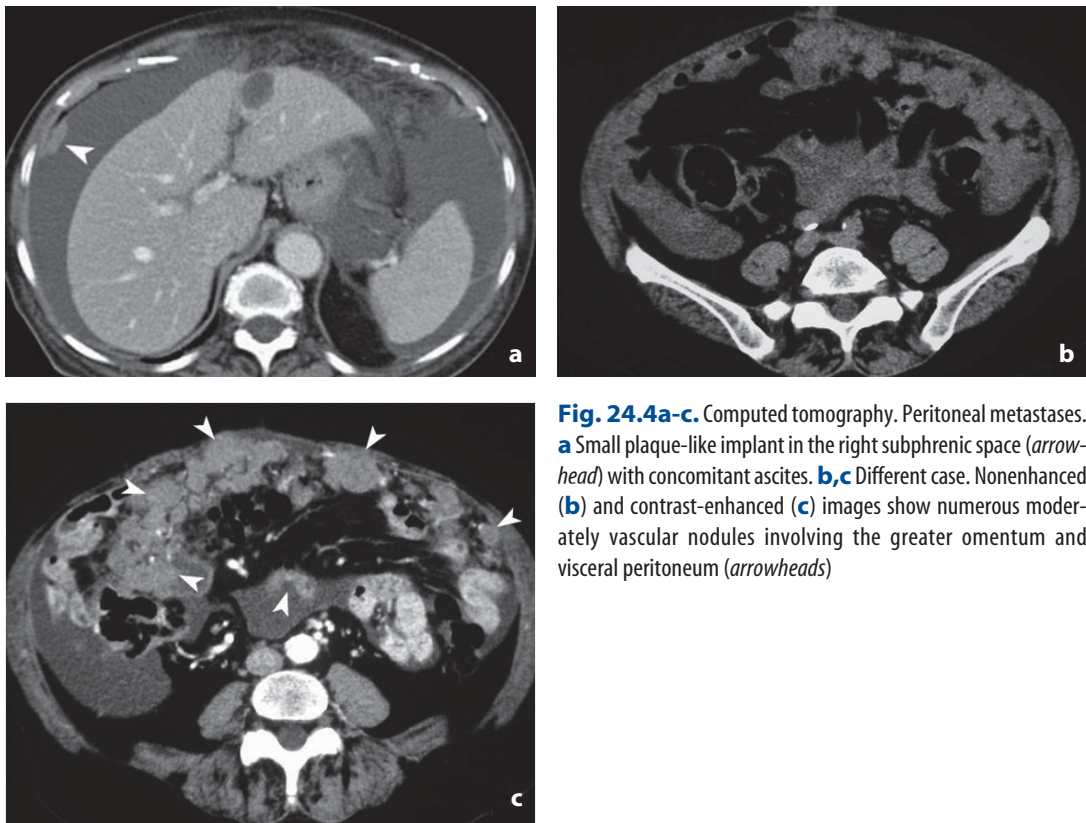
Computed tomography. Peritoneal metastases. a Small plaque-like implant in the right subphrenic space (*arrow-head*) with concomitant ascites. b,c Different case. Nonenhanced (b) and contrast-enhanced (c) images show numerous moderately vascular nodules involving the greater omentum and visceral peritoneum (*arrowheads*)
